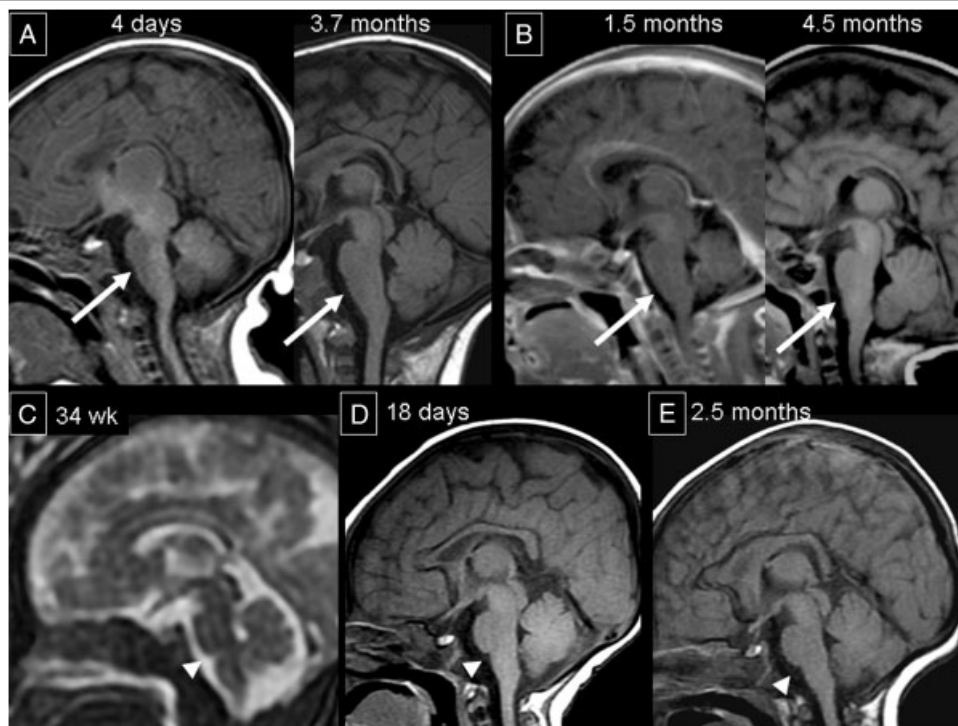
Brain MRI of the two patients and three controls. Note the abnormal shape of the brainstem with enlarged medulla oblongata eclipsing the ovoid form of the pons (arrows) on brain MRI (T1-weighted sagittal images) in both cases (top) compared to controls (bottom, arrowheads). A: Patient 1; B: patient 2; C: antenatal MRI of a control fetus at 34 weeks gestation; D–E: controls.
